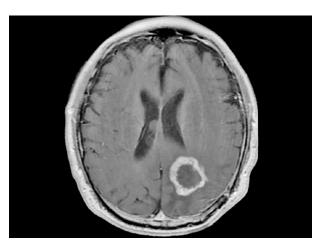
MRI brain showing ring enhancing lesion.
